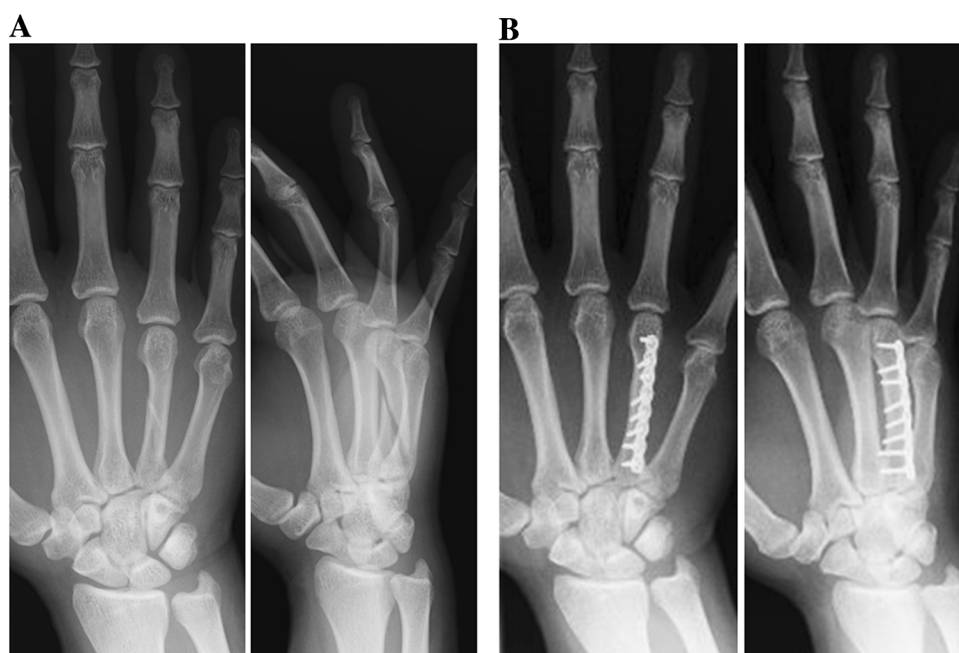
Case 20. Longer plate fixation is occasionally indicated for the purpose of rigid fixation for athletes to return early to competition or training, even though screw fixation is indicated. a Anterior-posterior and lateral radiograph before surgery. b Anterior-posterior and lateral radiograph after surgery
